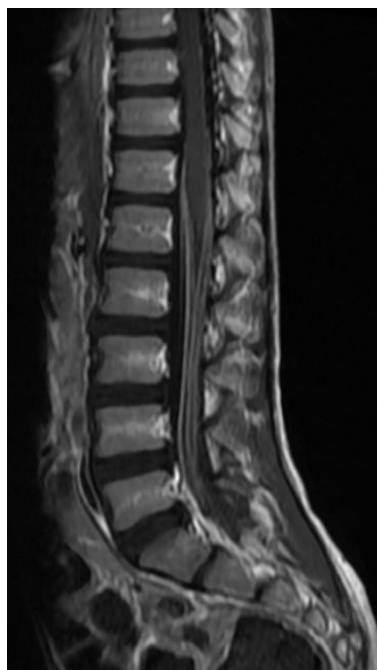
MRI Spine Sagittal T1 Flair with contrast showing cauda equina nerve root enhancement.
